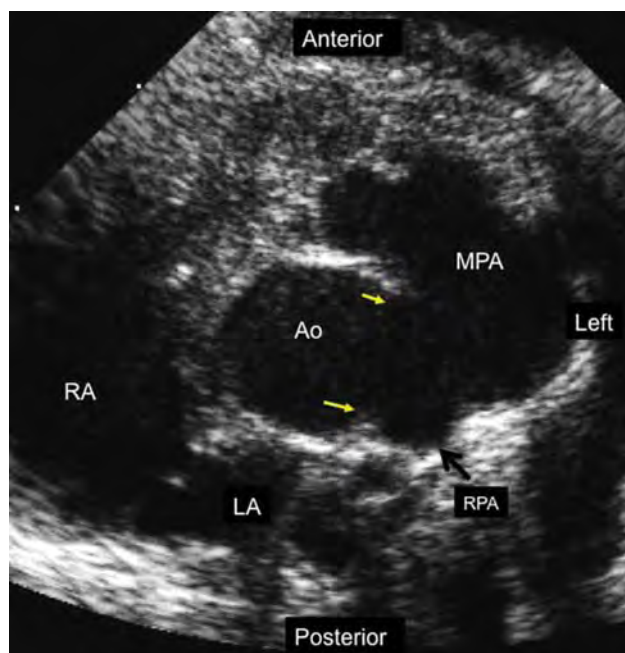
Aorto-pulmonary window. This is a horizontal (short axis) plane echocardiographic image demonstrating the proximal ascending aorta (Ao) in cross-section and the main pulmonary artery (MPA). The yellow arrows indicate the anterior and posterior edge of a large communication between the Ao and the MPA, an aorto-pulmonary window. In contrast to both an aorto-ventricular tunnel and a ruptured sinus of Valsalva aneurysm, this malformation has no “length.” Rather, it is essentially an absence of the walls separating the two great arteries. LA, left atrium; RA, right atrium; RPA, right pulmonary artery origin.
